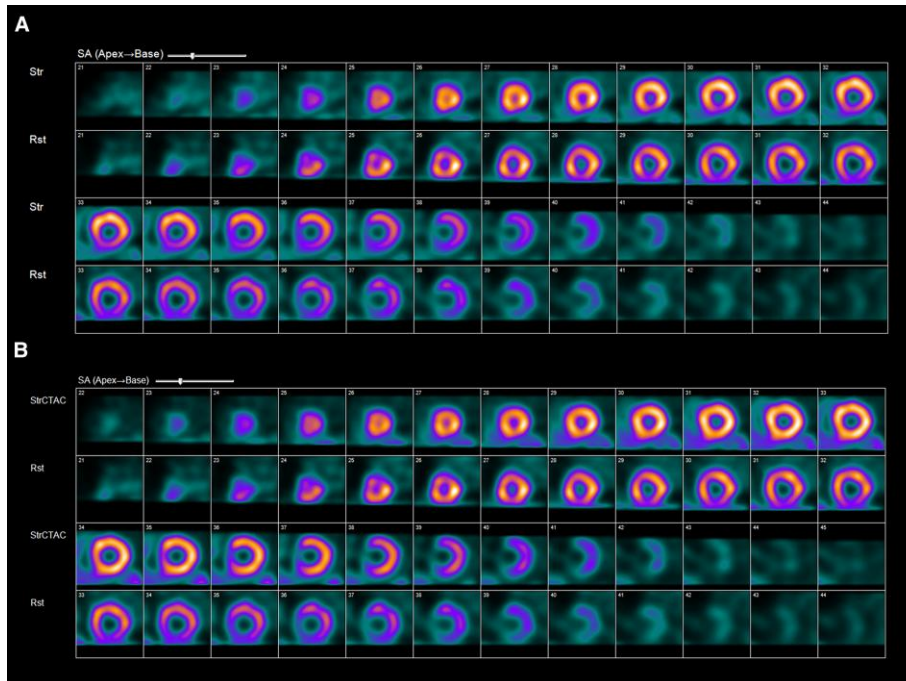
Myocardial perfusion SPECT imaging of a female patient with a body mass index of  $29 \text{ kg/m}^2$ . Selected slices (stress in the top row, rest in the bottom row) and corresponding polar plots of the reconstruction without attenuation correction (A) depict a reduction in counts particularly affecting the inferior wall. In contrast, attenuation corrected reconstructions (B) lead to a complete normalization, unmasking the apparent defect as an attenuation artefact.
